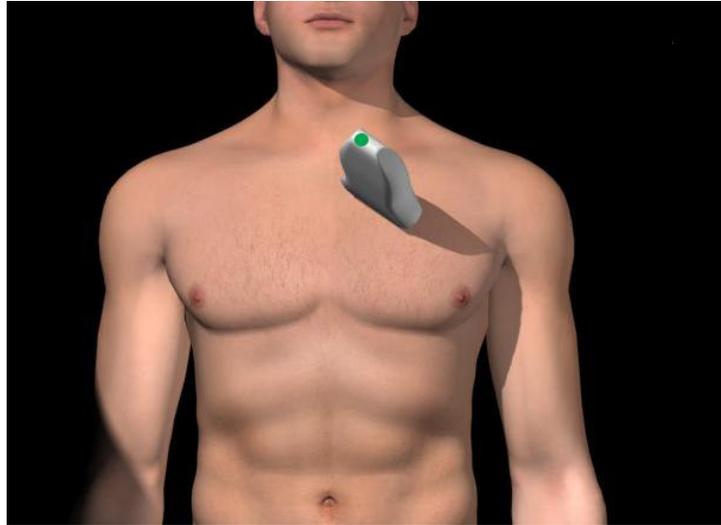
parasternal long axis view.*
